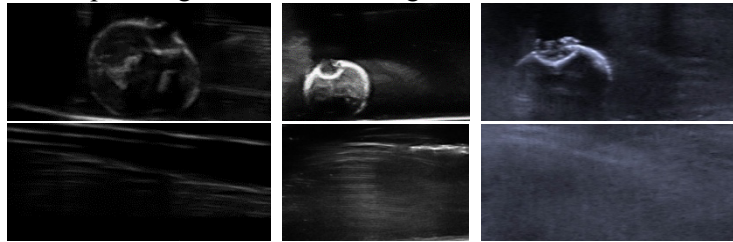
Sample Images. From left to right, Ultrasonix SonixTouch, Clarius L15, Siemens S3000.
